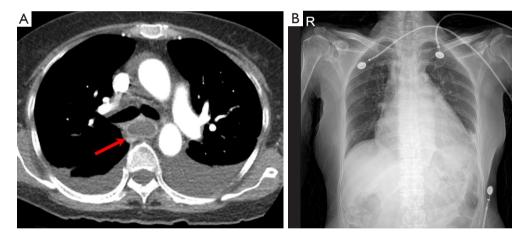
Follow-up CT scan and chest radiograph of a patient with emphysematous esophagitis with gastritis. A follow-up chest CT (A) performed 12 days later shows that all intramural air in the esophagus had disappeared, and there was mild wall thinning and fluid retention in the esophagus (arrow). Bilateral pleural effusion is also observed. A follow-up chest radiograph obtained 2 months later (B) shows no unusual findings other than subsegmental atelectasis in the left lower lung zone. CT, computed tomography.
